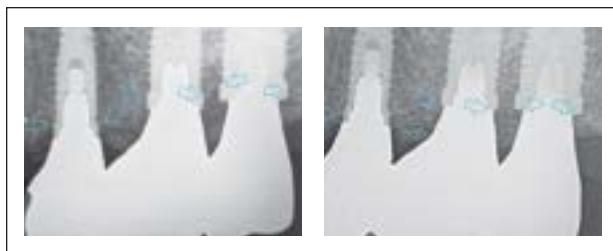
Radiographic comparison (left) before and (right) after the orthodontic procedure. Bone maturation is seen along the implant interface (yellow arrows). New bone formation is in progress within the peri-implant gap at both the mesial and the distal sides, significantly increasing the marginal bone level. Blue arrows indicate the most coronal BIC.
